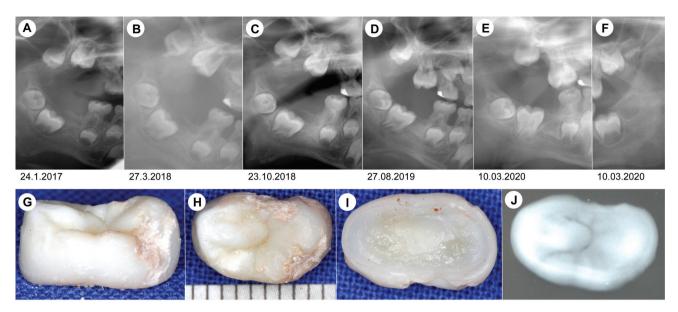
Supernumerary microdont of permanent dentition in neurofibromatosis type 1. (A-F) Cropped images of orthopantomograms taken between the 6th and 9th year of age (A-E show right mandibular angle, F shows left mandibular angle). (A) Detail of figure 1H: Crowns of right upper molars surrounded by thin bony trough (6-year-old). (B) Initial calcification of supernumerary tooth superimposing the occlusal plane of the second molar. (C) Further growth of a small radiopaque lesion different to the second molar's crown. The distance between the first and second upper molar is increased, and first molar's root is further developed. (D) First molar is moving in mesial direction and caudally after removal of tumorous mucosa and microdont (9-year-old). (E) Eight months later, the maxillary right first molar developed occlusal contact with mandibular deciduous second molar. (F) On the left side, third molars are developing in both jaws at the same time. Lateral (G), occlusal (H) and apical (I) photographs of the microdont after excision. Note opposing enamel mineralization disorders of the tooth (maximum length about 10 mm). (J) Contact radiograph of microdont shows enamel defects and inhomogeneous radiopacity.
